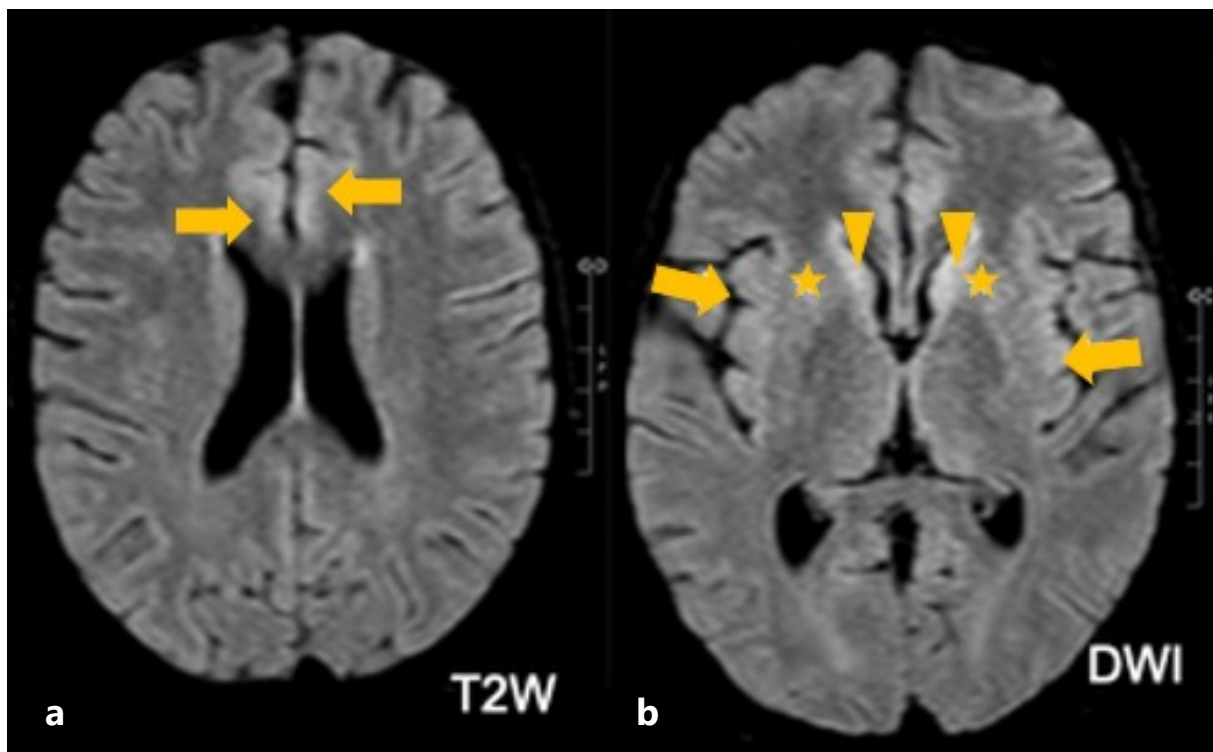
MRI brain of a patient with acute myeloblastic leukaemia, following peripheral blood stem cell transplantation [6]. There are abnormally high T2 signals in the bilateral medial frontal lobes (a), anterior putamina (b, asterisks), caudate heads (b, arrowheads) and insula (b, arrows). Findings may suggest, but not limited to, viral encephalitis.
